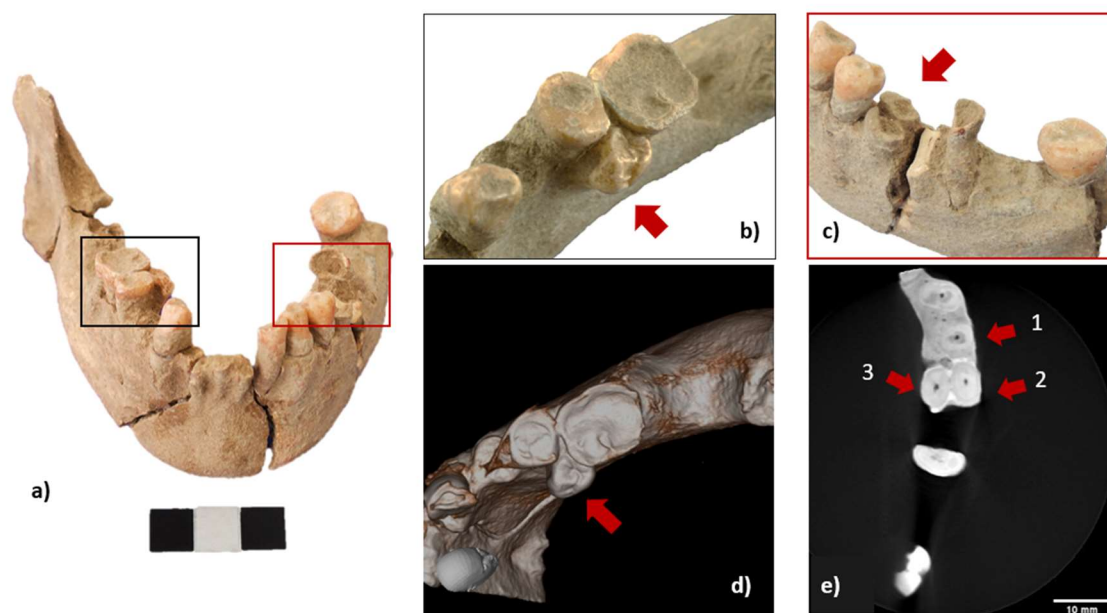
Grave 3 (Male, 40-45): Left panel: a): frontal/oblique view of the mandibula. Upper right panel: b) lingual view of the right mandibular premolar region with the supernumerary premolar, erupted on the lingual side of the mandibula between the fourth premolar and the first molar; c): buccal view of the left mandibular premolar region with the roots of the first molar, the fourth premolar, and a supernumerary premolar recognizable. Lower right panel: d): 3D volume rendering of the CBCT volume of the right hemimandible, occlusal view; e): axial reformatted image of the CBCT volume of the left hemimandible (slice thickness = 1mm) showing the roots of the third premolar (1) the fourth premolar (2) and the supernumerary one (3).
